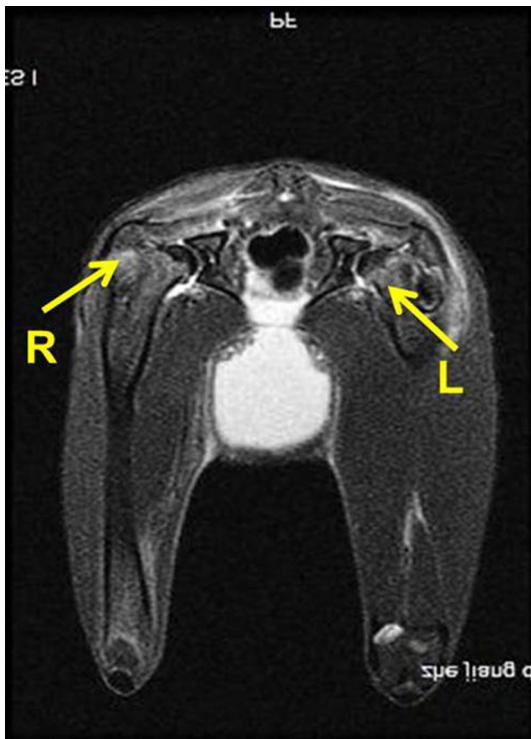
This MR image obtained 2 weeks after methylprednisolone injection showed signs of edema (arrows) in the proximal femur. R = right side; L = left side.
